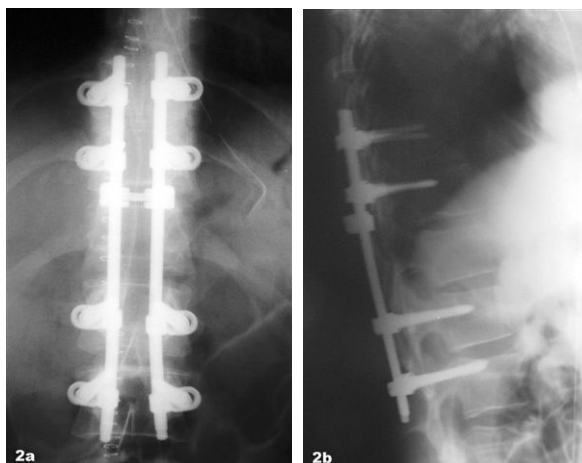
A, B, Postoperative x-rays following T10-L2 stabilization.
